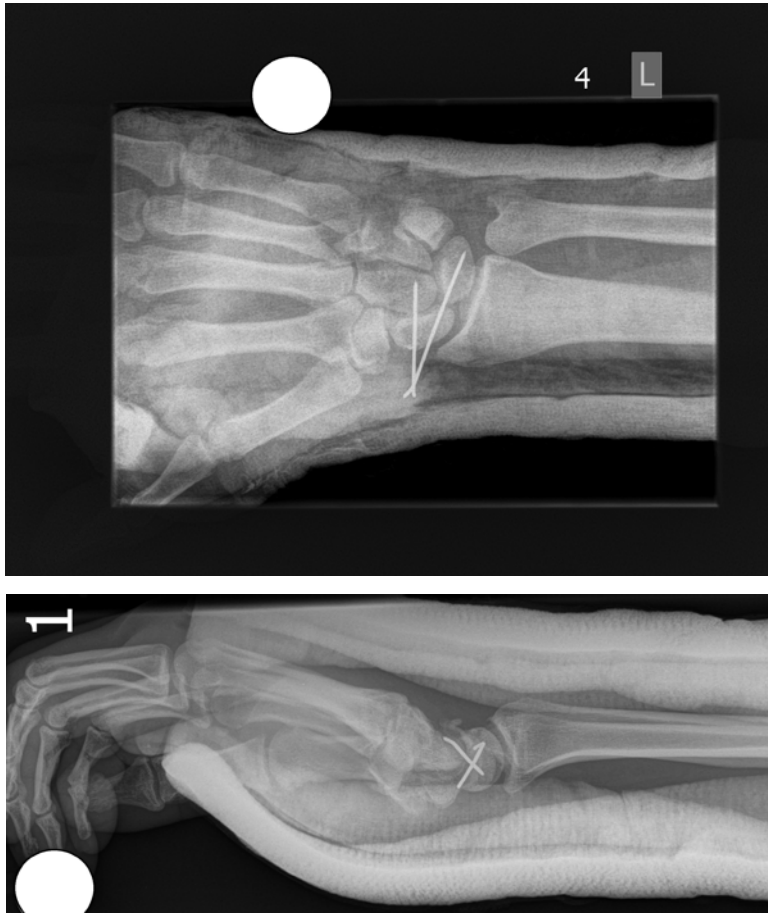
Postoperative X-rays to Show Anatomical Reduction and Wire Placement
